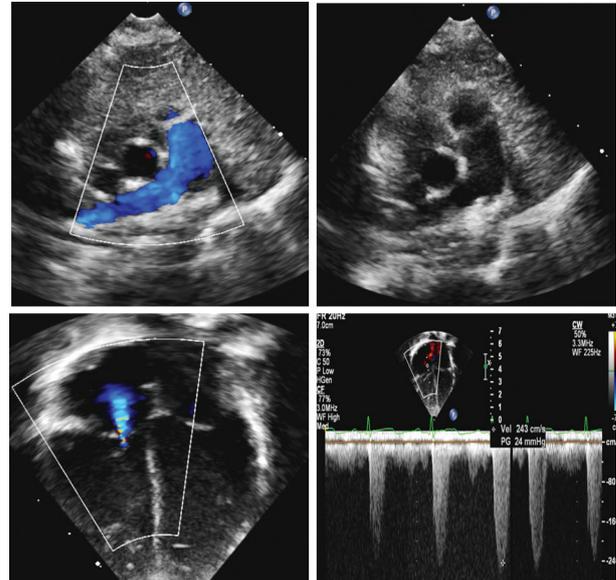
Echocardiography showing mild Tricuspid regurge with Peak systolic pressure gradient (PSPG) of 25 mmHg. Absent versus atretic LPA, good size Right pulmonary artery (RPA) with preferential blood flow.
